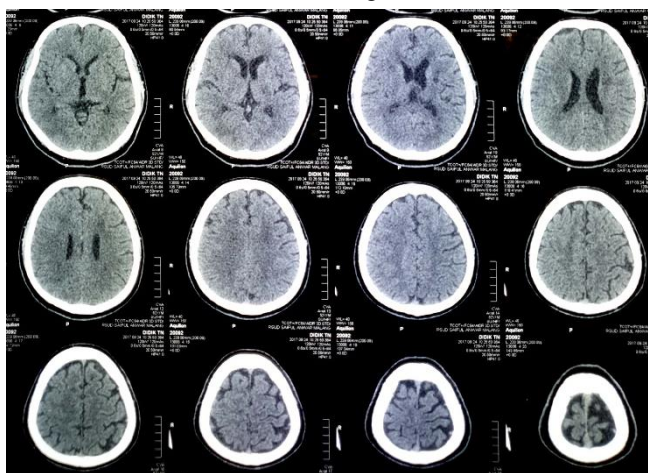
Head CT Scan, Brain Window without Contrast
